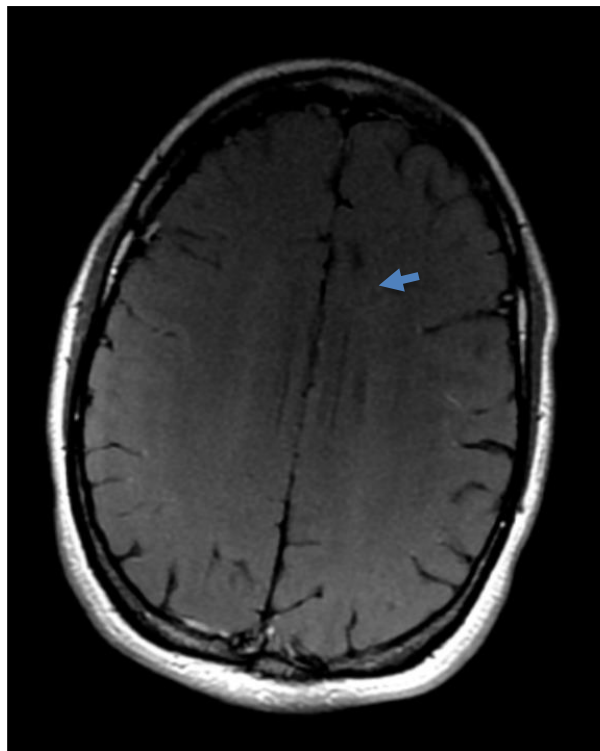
Axial contrast-enhanced T1-weighted image demonstrating thin peripheral enhancement of the white matter lesions (blue arrow).
